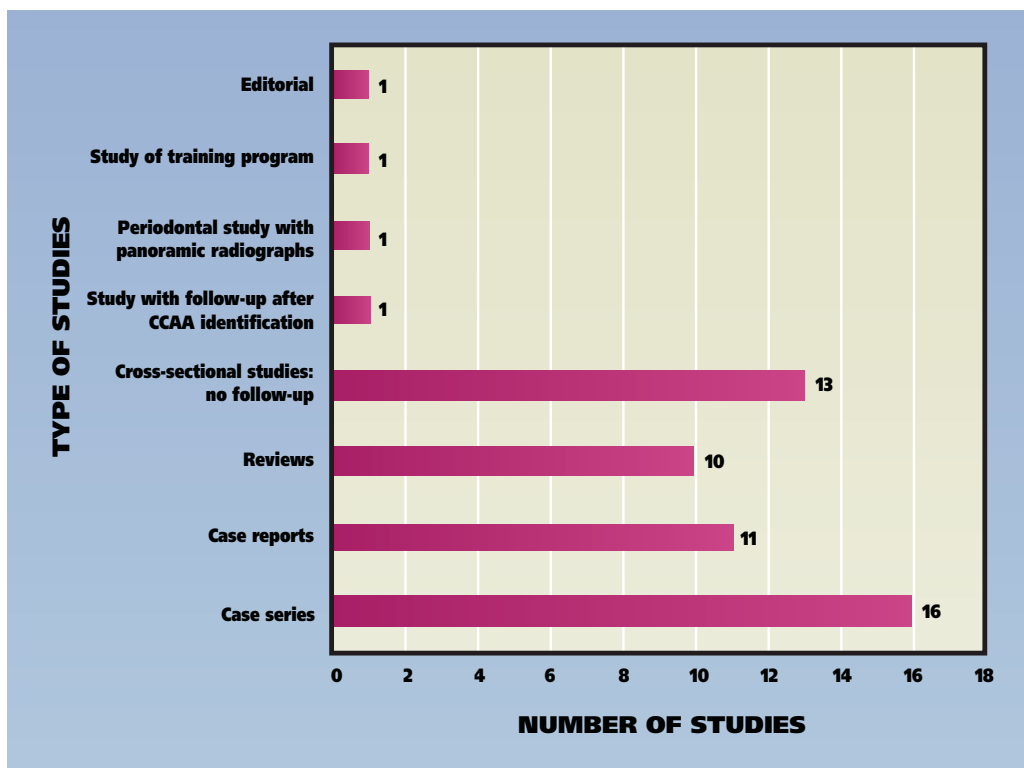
Graph showing the distribution of 54 selected articles that used panoramic radiographs to study calcified carotid artery atheromas. CCAA: Calcified carotid artery atheroma.
